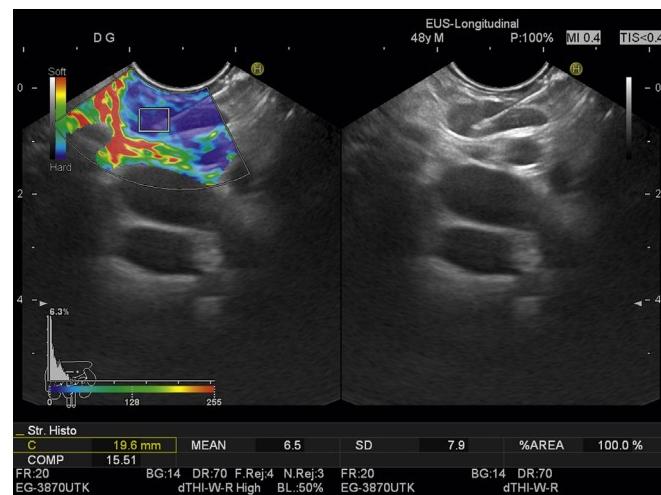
Malignant mediastinal lymph node. Endoscopic ultrasound elastography showing a relatively homogeneous mixture of blue, indicating a relatively hard structure as compared to the surrounding tissues (left).
